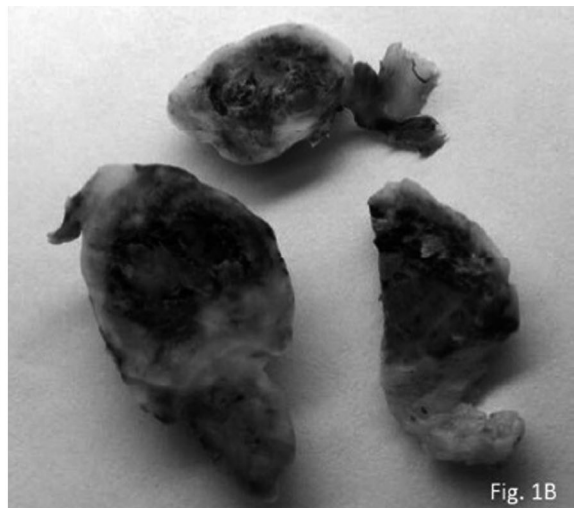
A: Ultrasonography: highly echogenic ovary, 5.25 x 4.56 cm in diameter. B: The tumoral mass has a yellow-grey cut surface.
